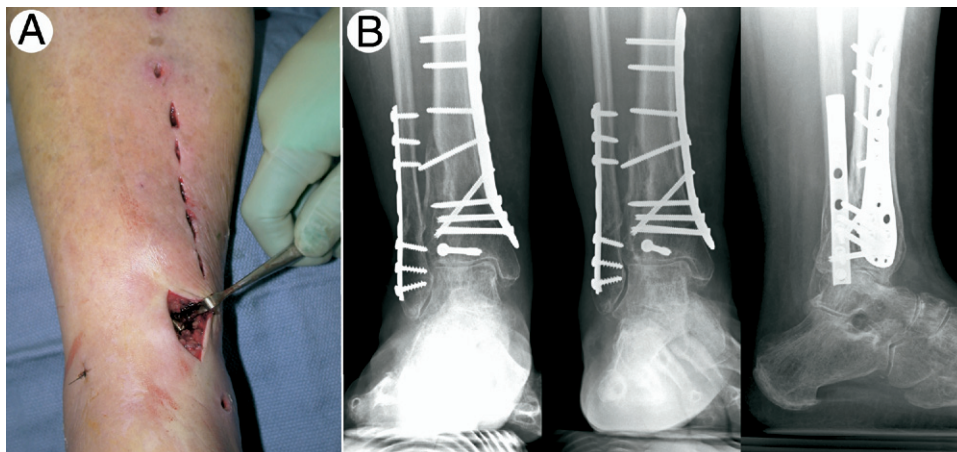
Same patient as [Figures 2](#) and [3](#). (A) Intraoperative photograph after the external fixator is removed and ready for percutaneous locking plate fixation. Percutaneous incision for medial locking plate to is medial to the tibialis anterior tendon. The plate is inserted through this incision suprapariosteally along distal medial border of the tibia. Stab incisions are created for placement of proximal (locking or nonlocking) screws. (B) Weight-bearing radiographs approximately 12 months from injury. The articular component is completely consolidated in good alignment.
